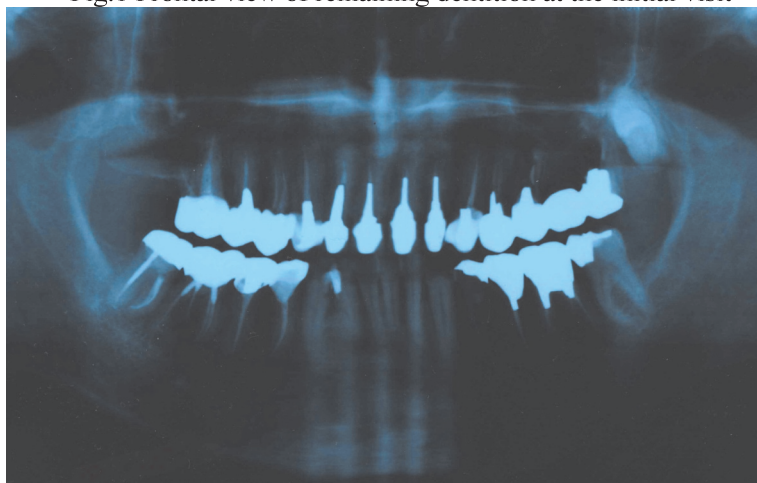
Panoramic radiograph at the initial visit
